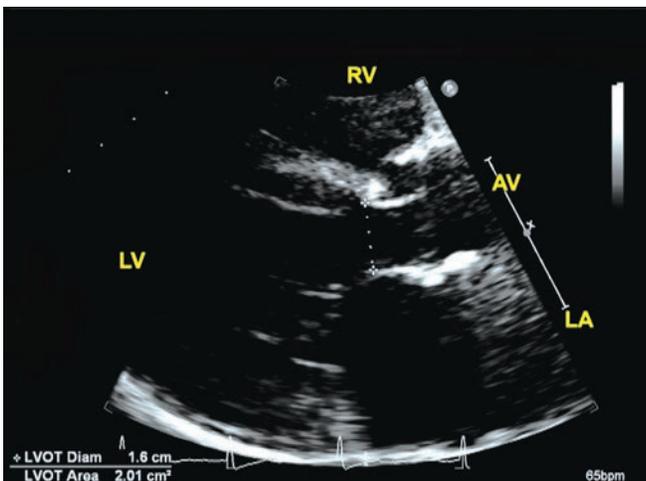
Parasternal long axis view.
